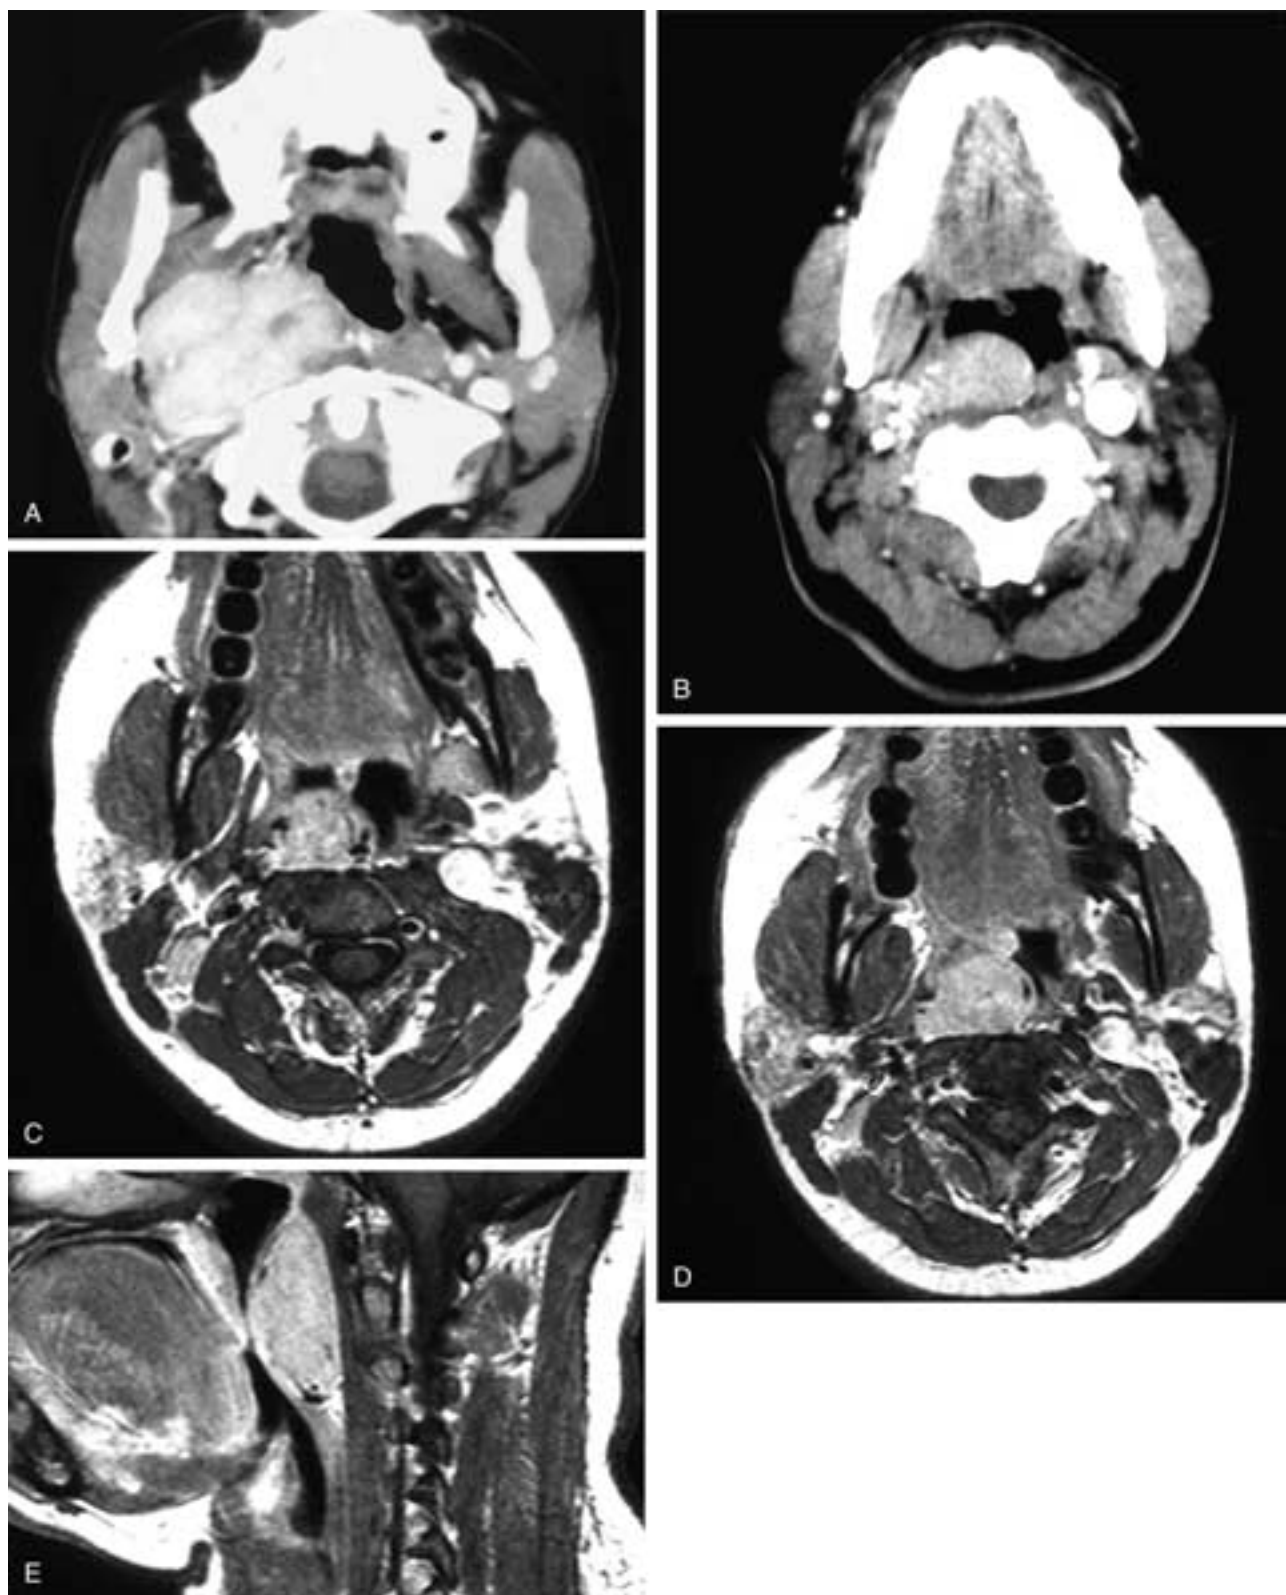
Axial contrast-enhanced CT scan (A) shows a large, enhancing mass in the right parapharyngeal space/carotid sheath region obliterating the silhouette of the internal carotid and internal jugular vein. The mass pushes the right pharyngeal wall forward and medially. At surgery, this was found to be Castleman's disease in a retropharyngeal node. Axial contrast-enhanced CT scan (B) on another patient shows findings similar to those in A; however, the enhancing mass is seen to be along the medial border of the carotid sheath, in the region of a retropharyngeal node. Axial T1-weighted images (C, D) show the mass to have an intermediate signal intensity with vascular flow voids. Sagittal T1-weighted, contrast-enhanced image (E) shows enhancement of the mass with vascular flow voids at its margins. At surgery, this was found to be Castleman's disease in a retropharyngeal node.
